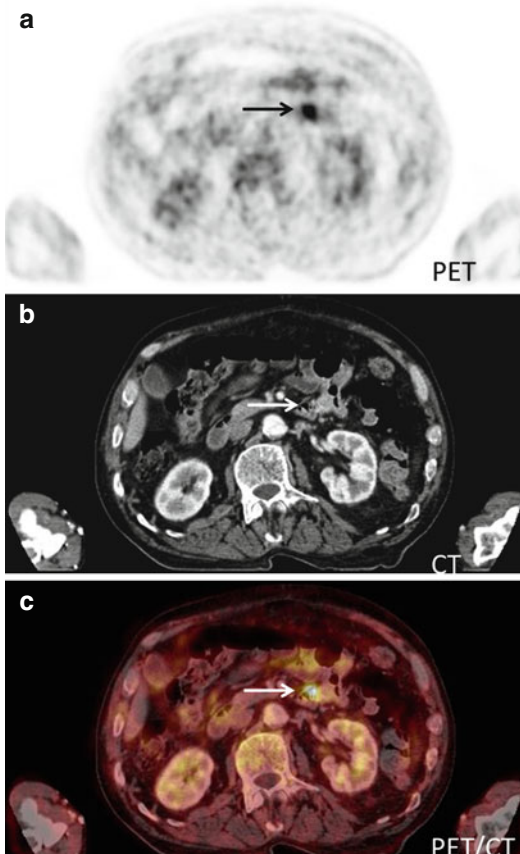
PET-CT showing irregular physiological FDG-uptake commonly seen in the bowels: (a) PET shows focal FDG-uptake in the abdomen (*arrow*). (b) CT shows high resolution anatomical images of the abdomen. (c) Fused PET-CT shows that the focal FDG-uptake correlates to normal configured intestines and therefore interpreted as physiologic FDG-uptake (*arrow*)
